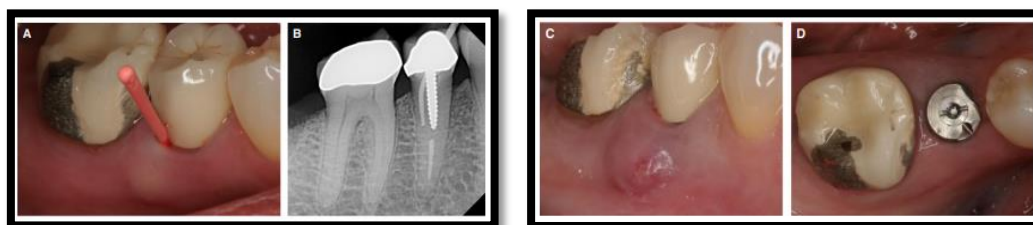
The clinical manifestations of complications from some root abnormalities can be comparable to primary endodontic disease with secondary periodontal disease. (A) The mandibular second premolar that received endodontic treatment was connected to a local deep pocket (traced with a gutta-percha cone). (B) Radiograph of a root cyst showing a gutta-percha cone pointing to the root area associated with the screw post. (C) The buccal plate was lost after an abscess formed on the buccal surface of the tooth. (D) Surgical examination revealed a fracture of the vertical root, the tooth was removed and replaced with an implant
